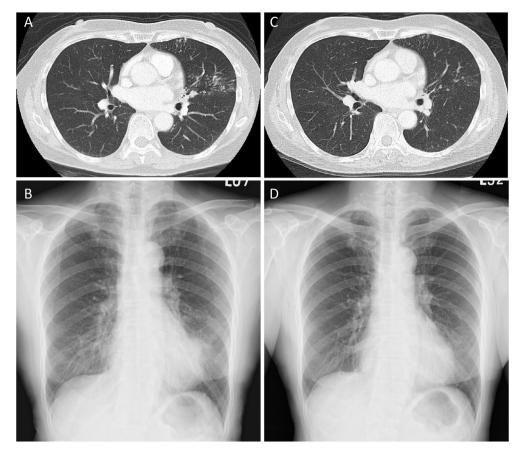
Non-cavitary nodular bronchiectatic pulmonary lesions in a 68-year-old woman with initial presentation of productive cough and hemoptysis lasting weeks. Her sputum samples were AFB culture positive for *Mycobacterium avium* complex (MAC). (A) Chest computed tomography (CT) reveals multiple small nodules, tree-in-bud lesions, and mild bronchiectasis in the lingular segment of the left upper lobe. (B) Plain chest radiograph indicates patchy consolidation in the lingular segment, consistent with peri-bronchiectatic inflammation. (C) Chest CT indicates that 7 months of three-times-weekly anti-MAC therapy with clarithromycin, ethambutol, and rifampin results in decreased extent of the tree-in-bud and nodular lesions. (D) Corresponding chest radiograph reveals improvement of consolidation in the lingular segment of the left upper lobe. Her symptoms improved and sputum samples were culture negative for MAC.
